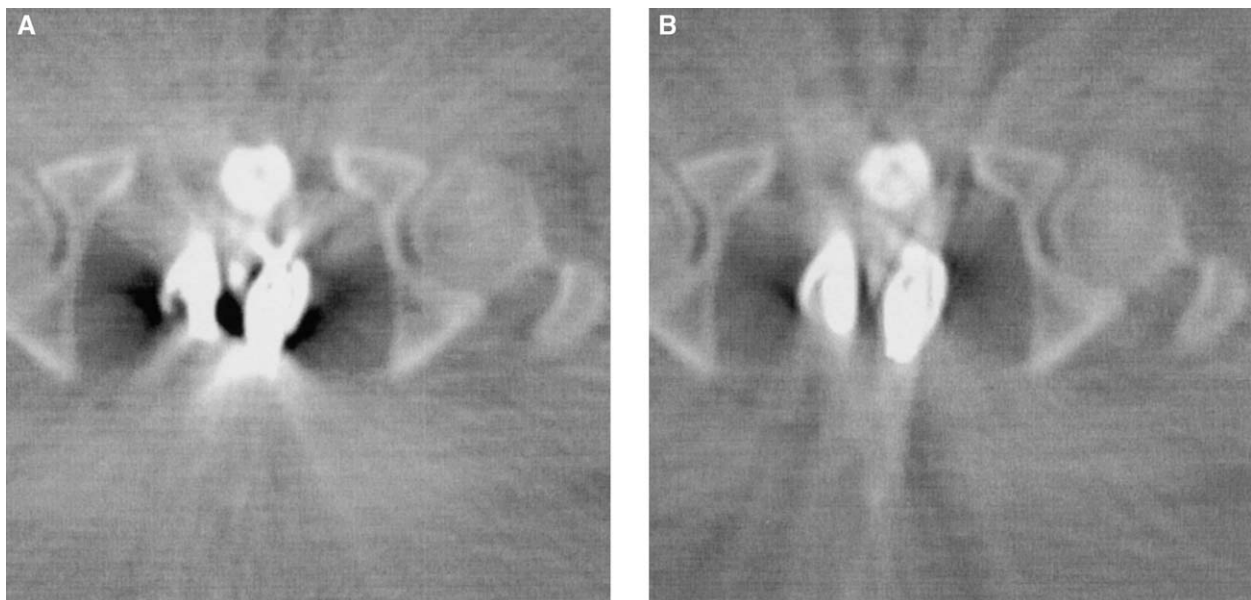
CT slice through the center of the colpostats (a) before and (b) after artifact reduction.
